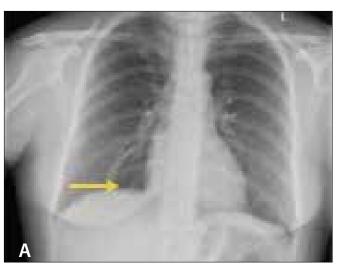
(A) Posterior-anterior view of the chest radiograph showing cysts (yellow arrow) in the lower lobes.
